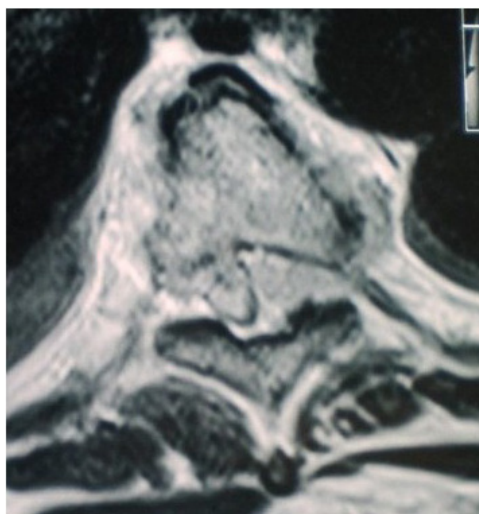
Axial T2-weighted MRI showing a homogeneous hyperintense lesion at T9 with relatively preserved contours, not affecting adjacent tissues.
